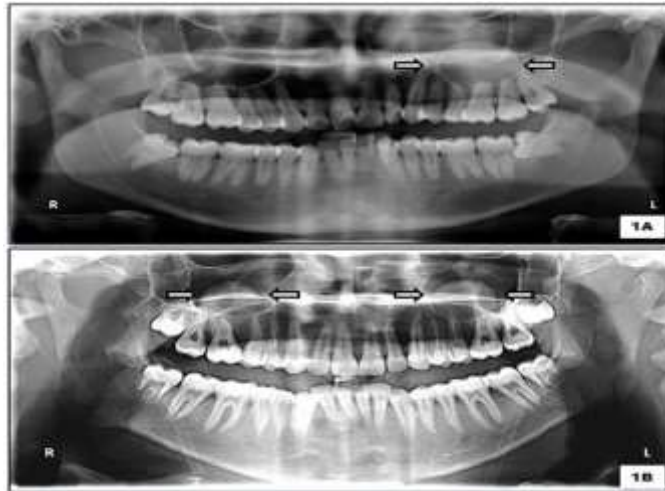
Orthopantomogram presenting a faint radiopaque, polypoid mass in left maxillary sinus (Fig. 1A) and in both right & left maxillary sinus (Fig. 1B) (white arrow)
